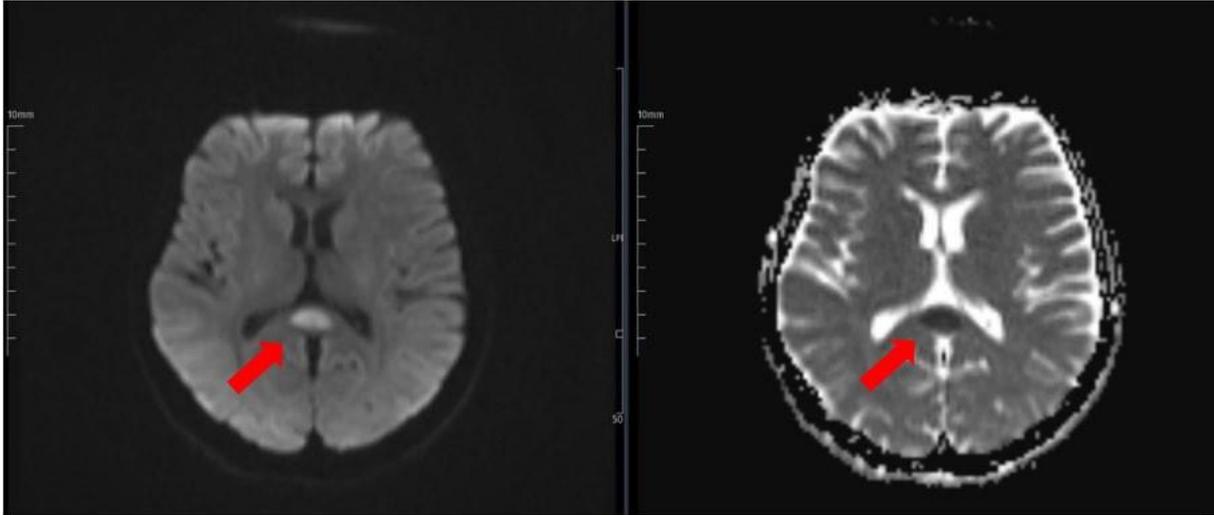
DWI MRI finding for Case 1. Hyperintensity in DAG images, hypointensity in ADC
